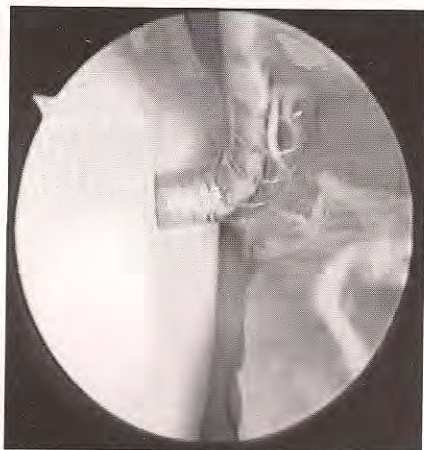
When hip pain persists despite normal findings on radiographs, CT, and MRI, arthroscopy can lead to a definitive diagnosis as in this case of paediatric chondromalacia coxae.
